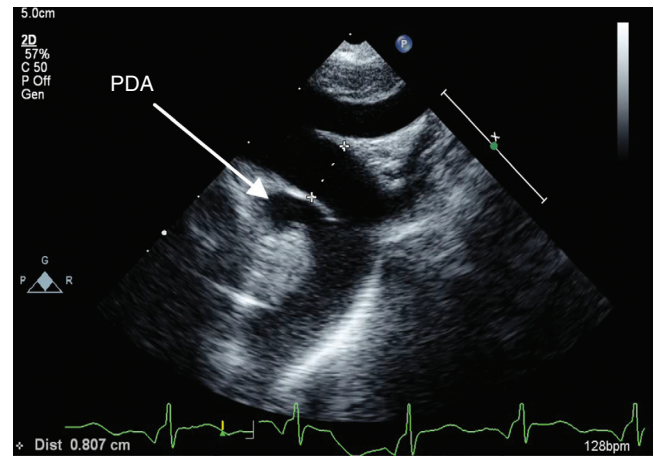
■ Echocardiographic appearance of the patent ductus arteriosus (PDA). Note the insertion just distal to the takeoff of the left subclavian artery.
